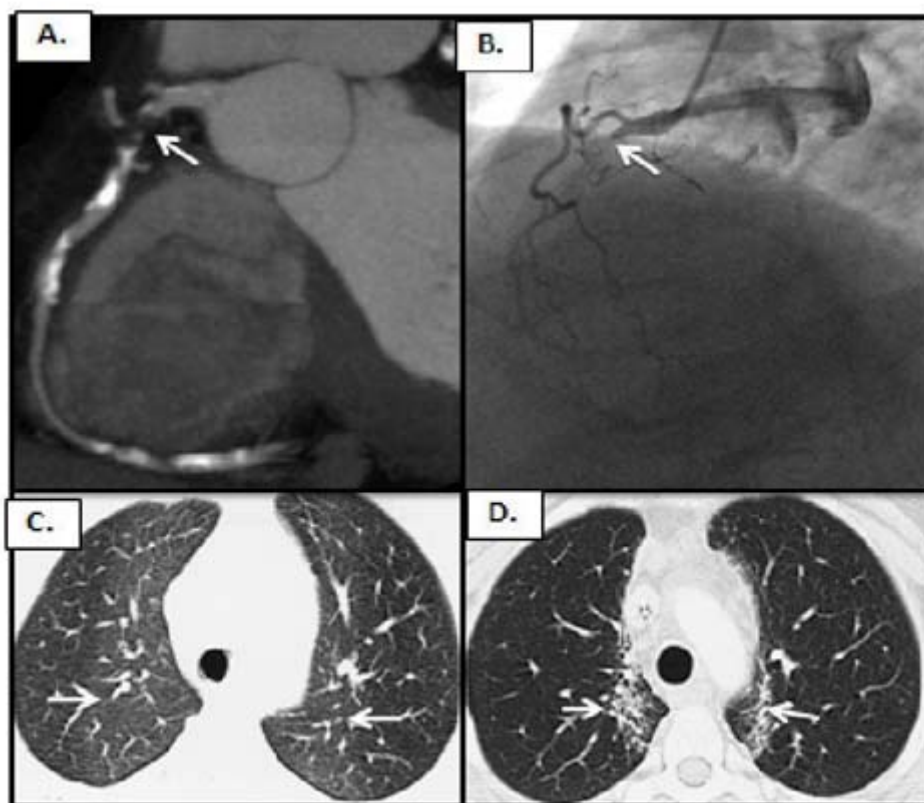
CT angiography of coronaries was performed in a 60-year-old male diagnosed with Hodgkin lymphoma (status postmediastinal irradiation) who presented with intermittent chest pain. MIP (maximal intensity projection) reconstruction. A: Soft plaque with total occlusion of the proximal right coronary artery. Invasive coronary angiography. B: Total occlusion of the proximal right coronary artery (arrow). CT scan obtained with narrow window settings 16 weeks after completion of radiation therapy. C: Subtle, paramediastinal, ground-glass attenuation in the upper lobes (arrows), a finding indicative of radiation pneumonitis. A CT scan obtained 11 months after completion of radiation therapy. D: Organization of the radiation pneumonitis into the typical paramediastinal pattern of fibrosis (arrows).
